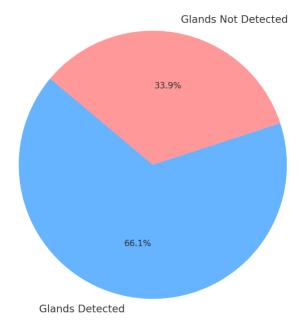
pie chart showing the detection rate of normal parathyroid glands via ultrasound among the 62 patients
